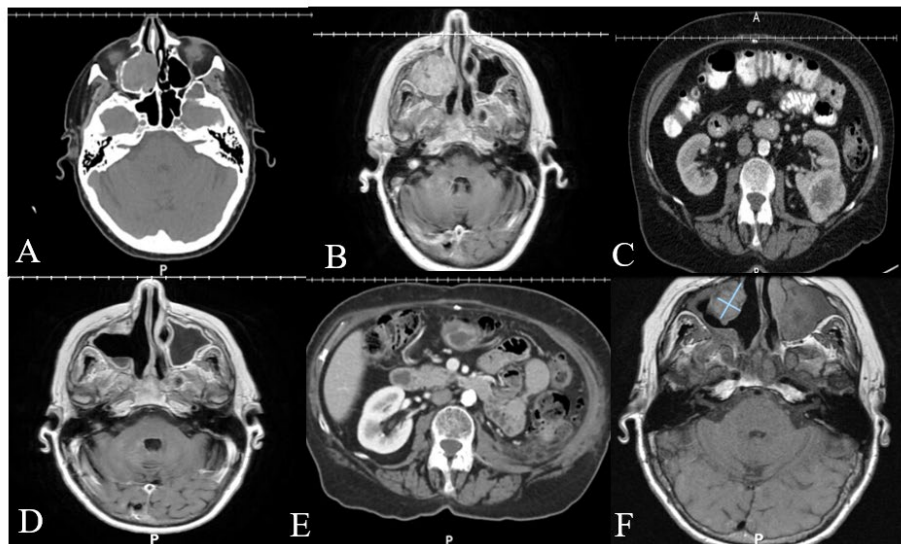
Patient Imaging (A) Initial CT sinus without contrast showing right sided sinonasal tract mass. (B) Follow-up MRI brain imaging confirming R-sided mass. (C) CT abdomen and pelvis showing left sided 4.9 cm renal mass (D) MRI brain imaging at 10-months status-post mass resection and immunotherapy showing resolution of mass (E) MRI abdomen and pelvis imaging 2-months post-cytoreductive nephrectomy (F) MRI brain imaging 2-months post-cytoreductive nephrectomy showing recurrence of right sided mass, noted with blue "X".
